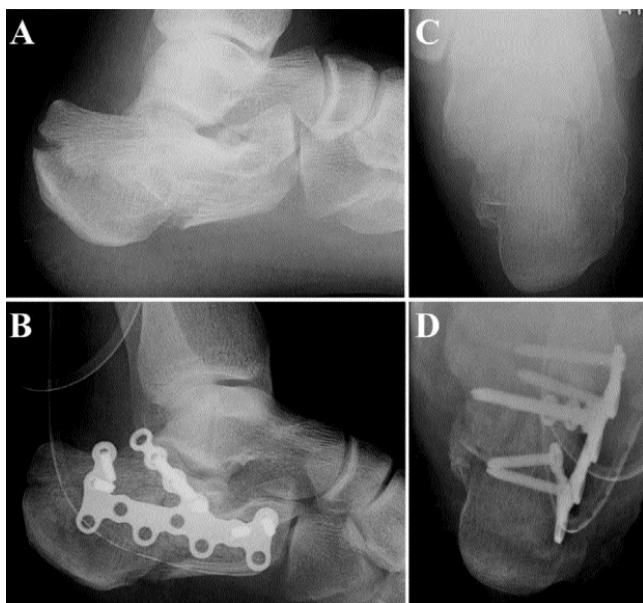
(A-D) Pre-operative (A-lateral, B-axial) and post-operative (C-lateral, D-axial) X-rays. Fixation has been done with calcaneal locking plate having obliquely aligned screw slots for the subarticular bone below the posterior facet (these screws also catch the medial sustentacular fragment as seen on the axial view), and slots for the anterior process and posterior tuberosity.
